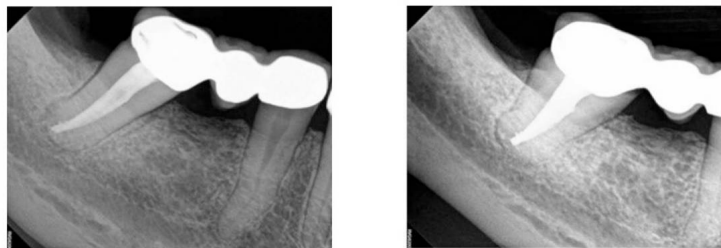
(E, F) Four-year post-operative radiograph
